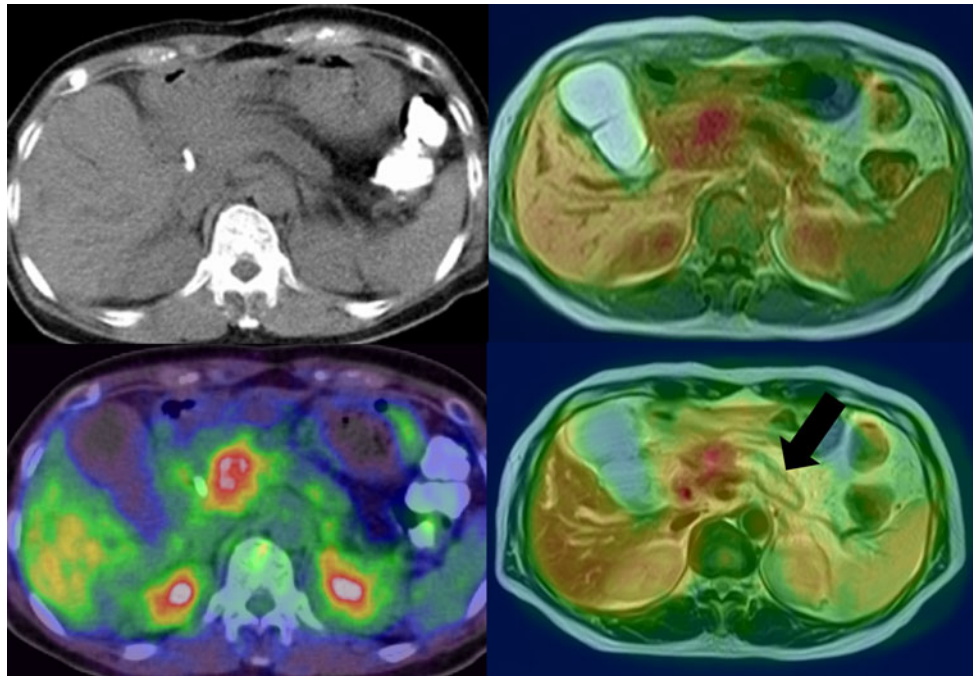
Although low dose CT did not show any abnormal density area (*left upper*), PET/CT showed intense uptake in accord with pancreatic head cancer (*left lower*). Both PET/MRI-T1WI fusion
